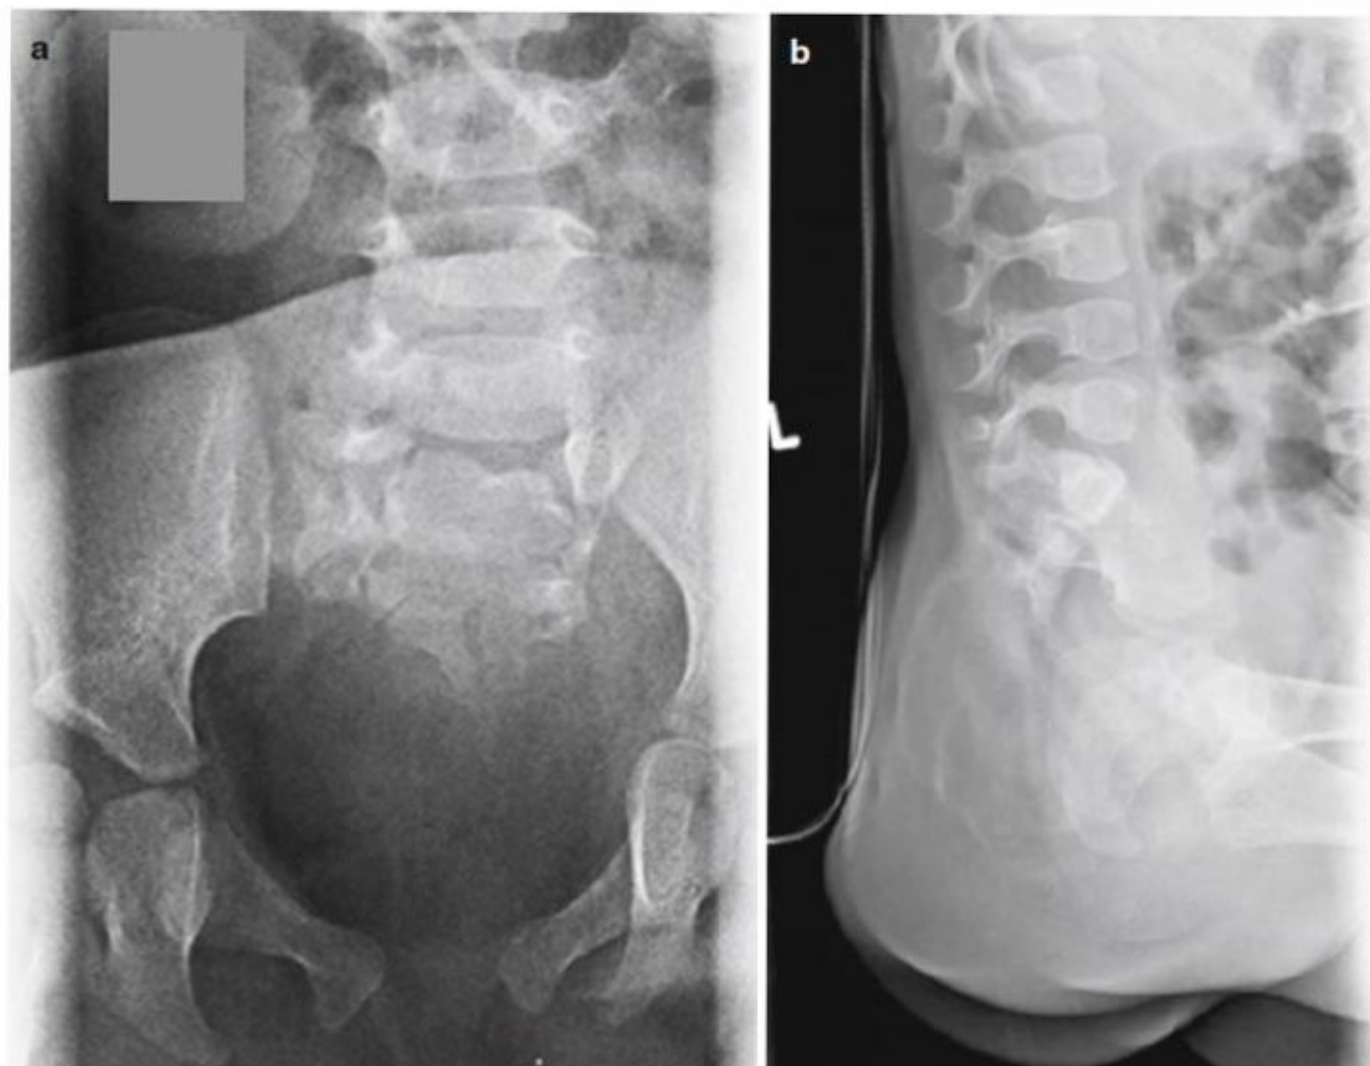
X-ray films of an abnormal sacrum in a baby with an anorectal malformation. (a) AP view. (b) Lateral view
